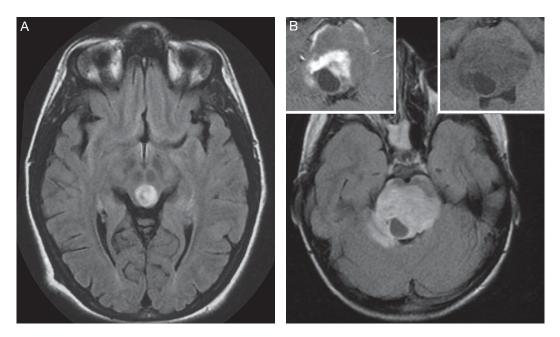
Magnetic Resonance Images of Brainstem Glioma.
